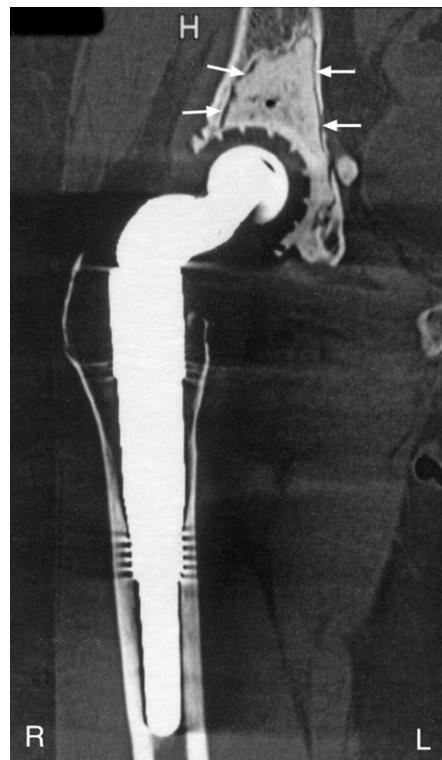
CT right hip performed 5 years following right total hip replacement and excision of metastasis. (A) Coronal image. Note the lucency at the cement-bone interface at the cortex of the right ilium (arrows) without evidence of significant osteolysis.
